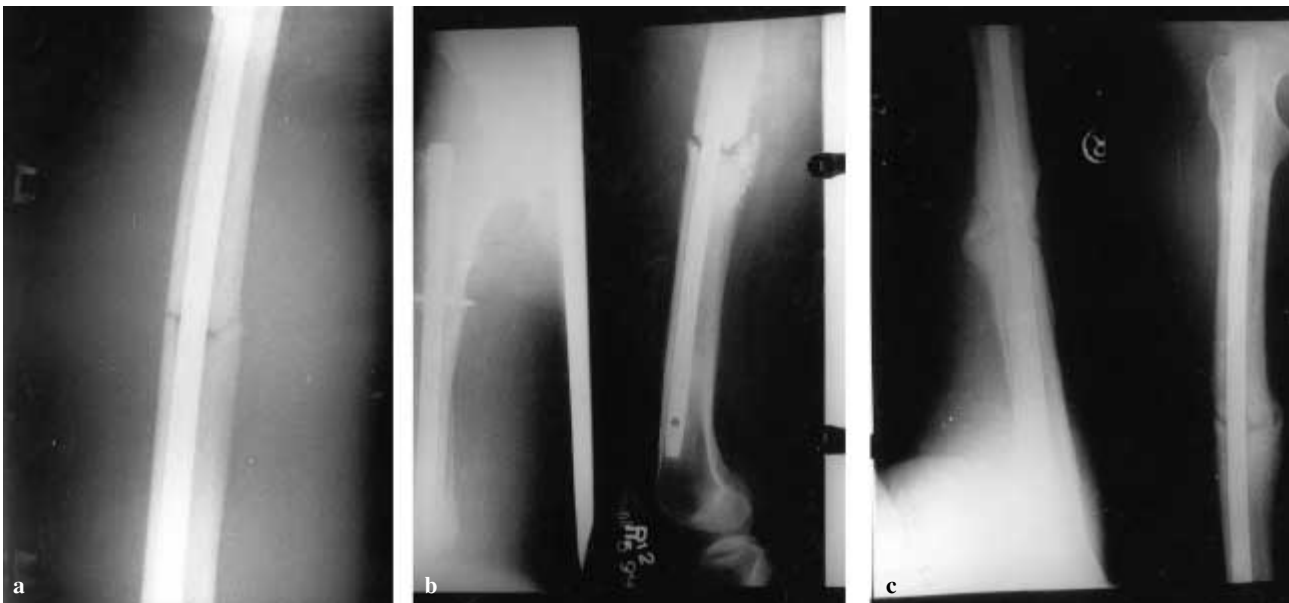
a. postoperative radiographs ; b. 12 weeks postoperative radiographs-date of dynamization ; c. 28 weeks postoperative radiographs.
